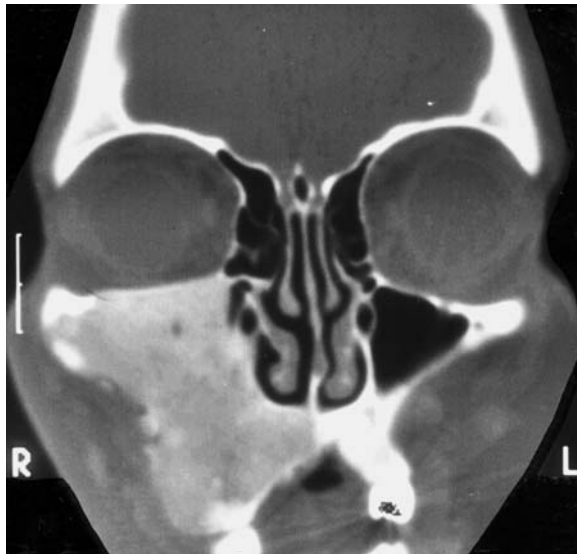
A 15-year-old girl with facial deformation in the absence of visual problems. Diagnosis: fibrous dysplasia (Jaffé-Lichtenstein disease). Coronal CT, showing characteristic sclerosing of the entire maxillary bone, leading to deformation of the right orbital floor
